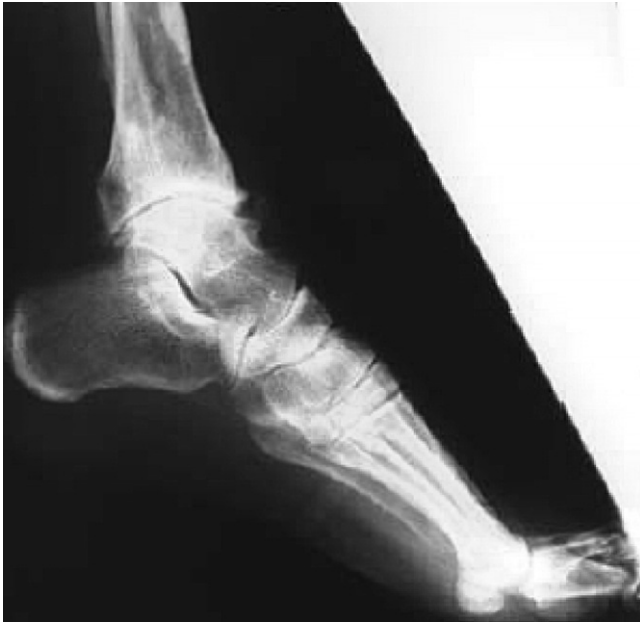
Typical pre-operative ankle lateral weightbearing x-ray.
